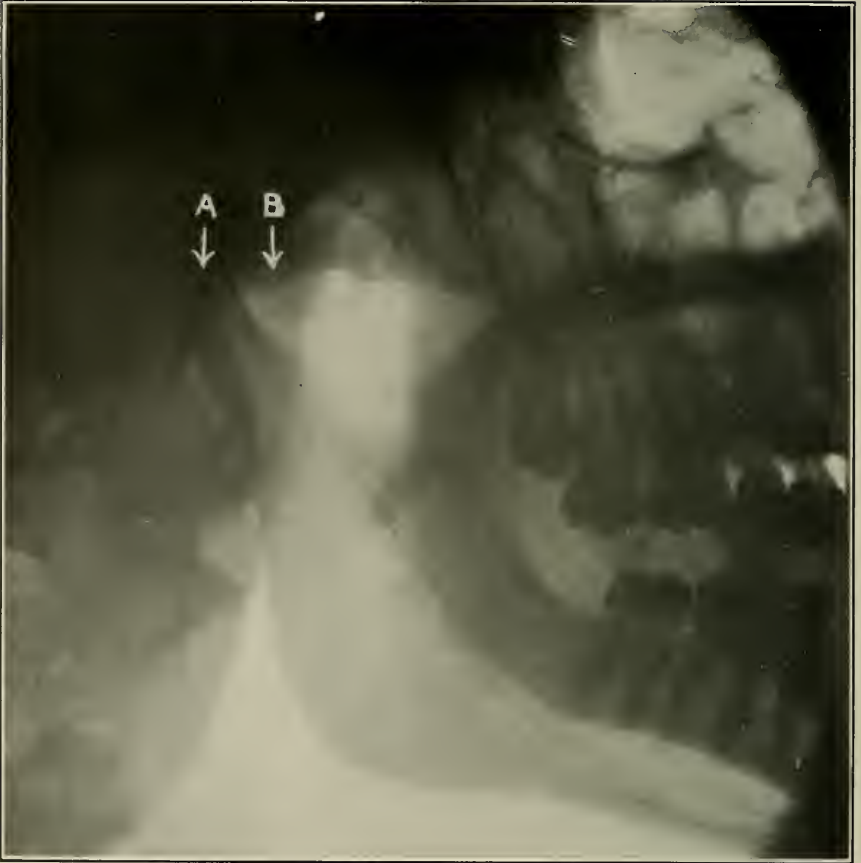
Same as Fig. 283 after reduction of the dislocation. A, condyle. B, eminentia articularis. (Radiograph by Cole and Raper.)
